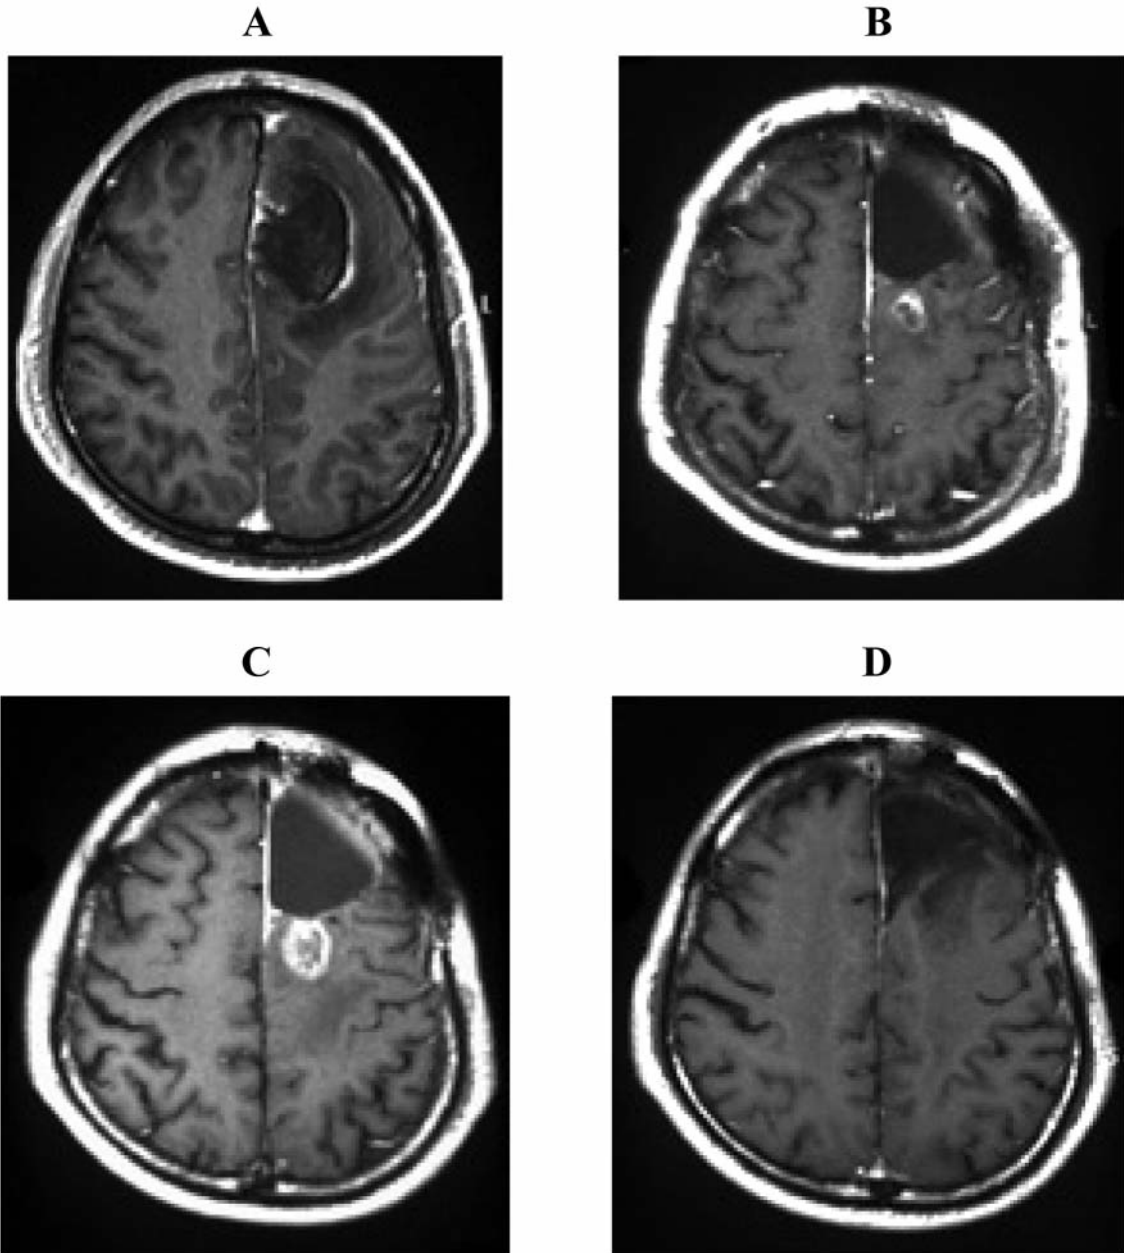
Case 1 with glioblastoma multiforme. Gadolinium-enhanced MRI before surgery shows a left frontal mass lesion with annular enhancement (A). Residual tumor post-radiotherapy MRI (B). Remnant tumor after finishing 3 cycles of TMZ regimen (C). Shrinkage of the lesion on serial MRI after finishing 13 TMZ cycles (D).
